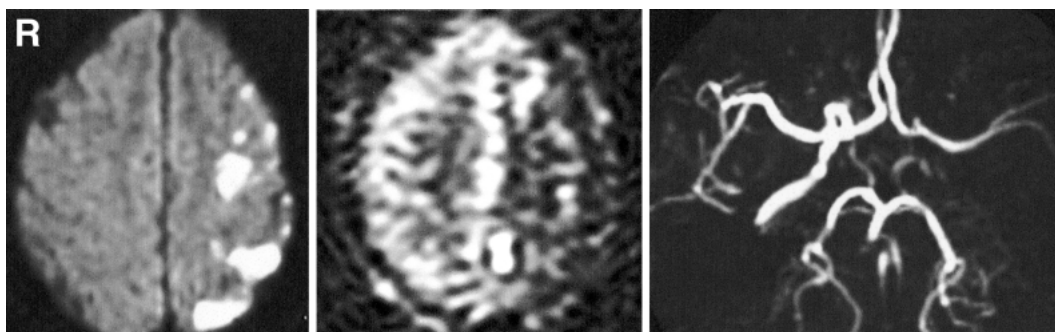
left*: Diffusion-weighted magnetic resonance (MR) image obtained at admission demonstrates high-intensity foci in the left frontoparietal cortex, indicative of fresh infarcts. *center*: Perfusion-weighted MR image demonstrating a diffuse low-intensity area in the left cerebral hemisphere, indicative of hypoperfusion of the left middle cerebral artery territory. *right*: MR angiogram demonstrating occlusion of the left internal carotid artery.
